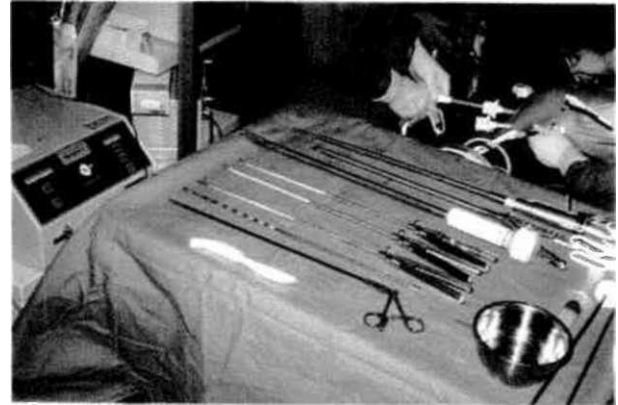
The instrumentation table shows (from below) forceps, rod, flamingo tie and tissue holder (x2) needle driver, purse string suture clamp, special needle holder for the purse string suture, and ultrasound dissection probe. Left of the table the ultrasound generator (Sonoco, Spring Ltd., Quickbom/Hamburg). Above right: the laparoscopic access ports.
